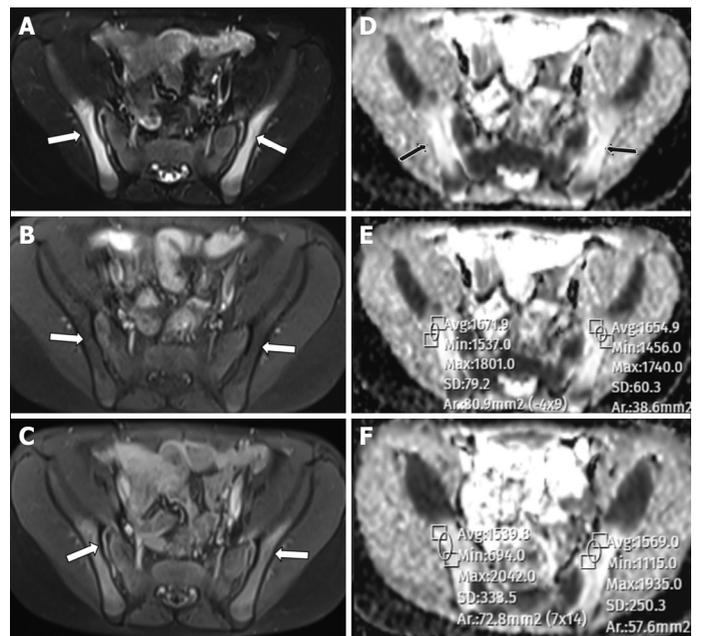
MRI images of a 15-year-old diagnosed with JIA. In the subchondral iliac bones adjacent to the SIJ, a hyperintense signal (A) in STIR images and hypointense signal (B) in T1W images consistent with bone marrow edema is observed. Diffuse enhancements are observed in the sacral bones adjacent to the sacroiliac joint in postcontrast images (C). There are ADC maps in the left column (D–F) and ADC values measured in the subchondral bone marrow in a patient with sacroiliitis (mean: $1.35 \times 10^{-3} \text{ mm}^2/\text{s}$).
